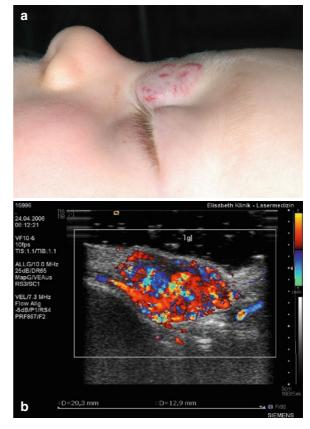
(a) Status after three sessions of cryotherapy; brightening of the superficial infiltration but increasing subcutaneous volume. (b) Color-coded duplex sonography shows the unaffected deeper pathological vessels down to 13 mm
